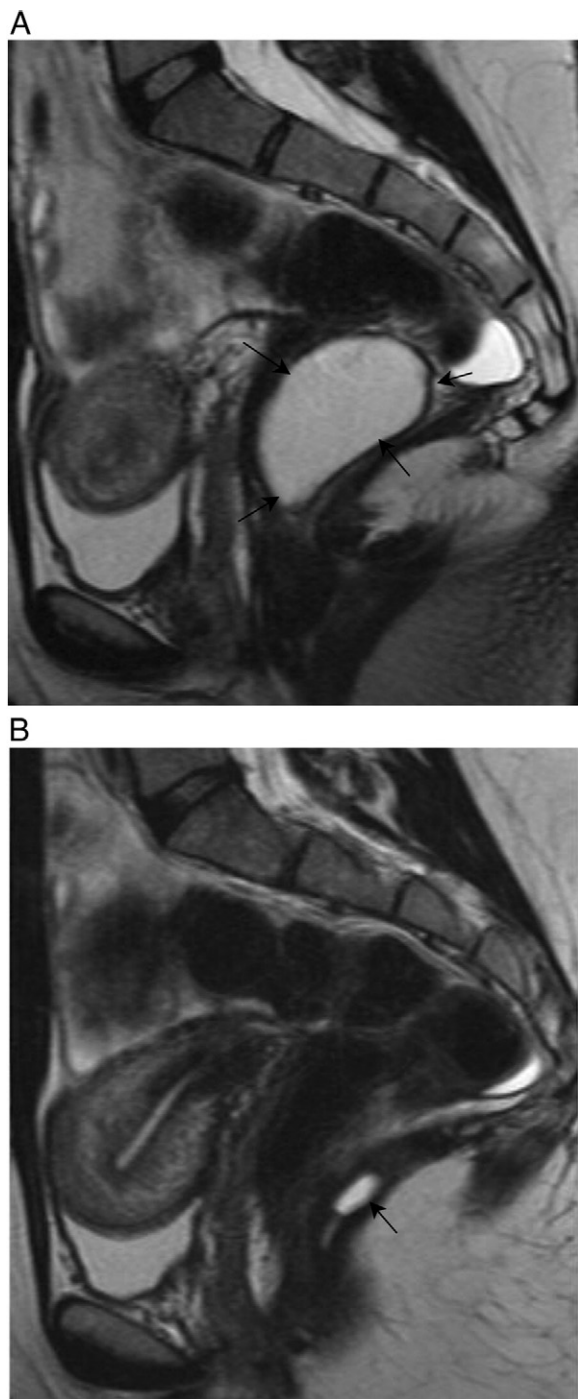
(A and B) Tailgut cyst in a 45-year-old female patient fortuitously discovered. Sagittal T2-weighted MR images demonstrate a retrorectal large cystic lesion (arrows, A) associated to two inferior small cysts (arrows, B).
